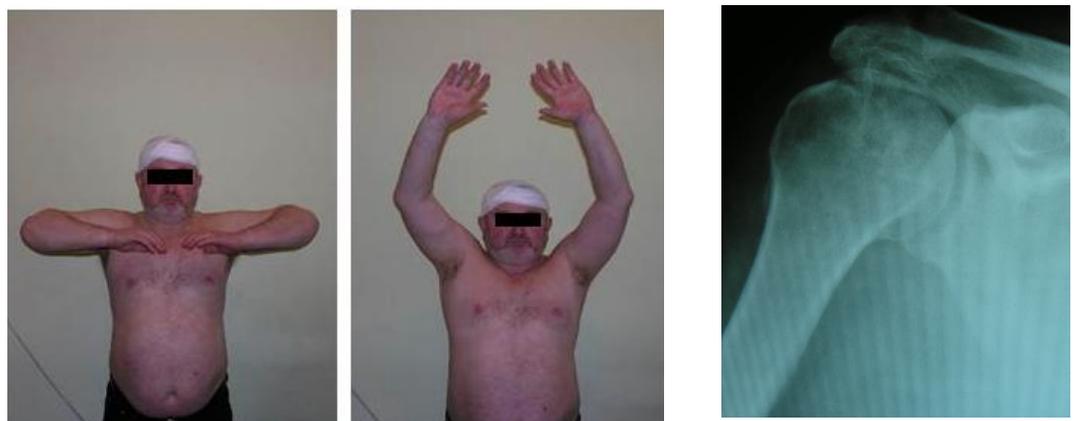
Radiographs of the shoulder joint and the patient B. 52 years old, two years after surgery. Arrow indicated mesh implant of the nickelid titanium in the subacromial joint, treat result is excellent.
